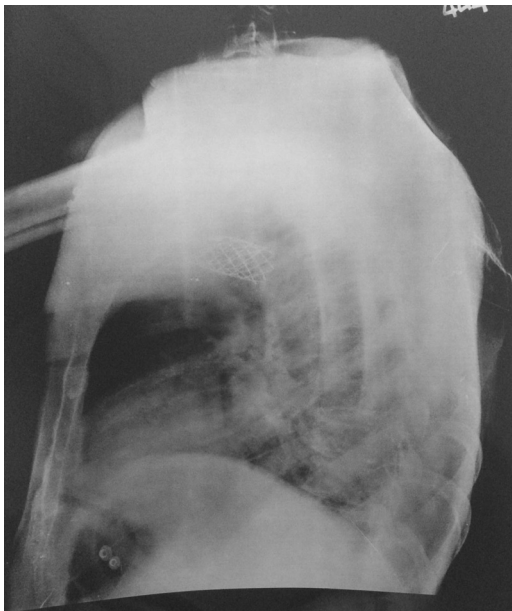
Chest X-ray lateral view showing stent in descending aorta.
